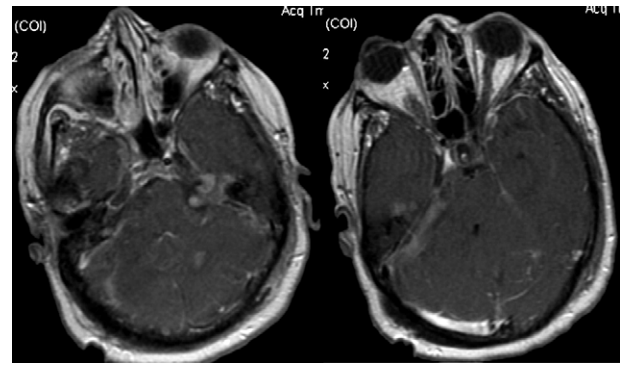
Postoperative axial T1-weighted MRI scans with gadolinium showing gross total resection of right acoustic neuroma.
